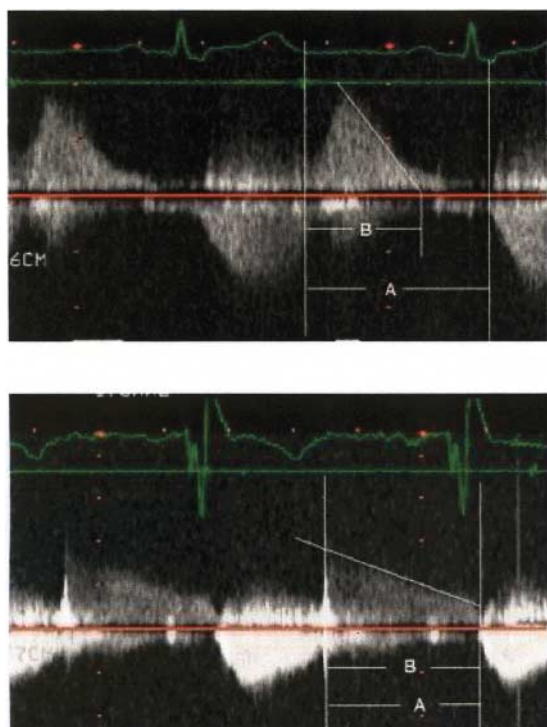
Severity of PR assessed by continuous wave Doppler. Continuous wave Doppler echocardiographic recordings of pulmonary flow from a patient with severe (top) and mild (bottom) PR. The duration of regurgitant flow (B) with respect to total diastole (A) is shorter in the patient with severe PR (top). Used with permission from W. Li, *Am Heart J*, 2004;147:165–172.
